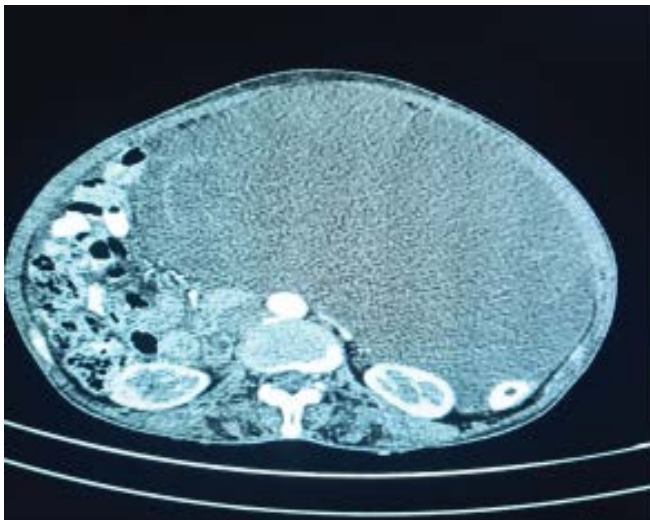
CT scan of the abdomen showing gross presence of large left ovarian multilocular cyst with gross ascites.
